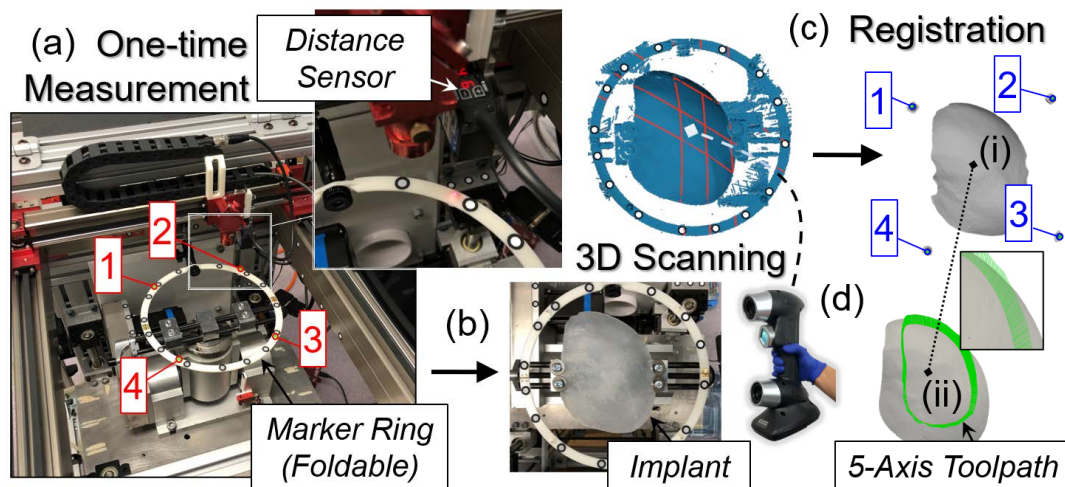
Implant registration using a 3D scanner (a) Performing an one-time measurement using the distance sensor to record the coordinates of the four registration points on the marker ring. (b) After mounting the implant on the rotary's fixture platform, a handheld 3D scanner is used to generate a 3D mesh of the implant including the surrounding marker ring. (c) The 3D scanned mesh can be registered to the machine coordinates system using the four correspondent registration points. (d) The generated 5-axis toolpath can be transformed to the laser space after registering the CT implant model to the 3D scanned implant model via ICP.
